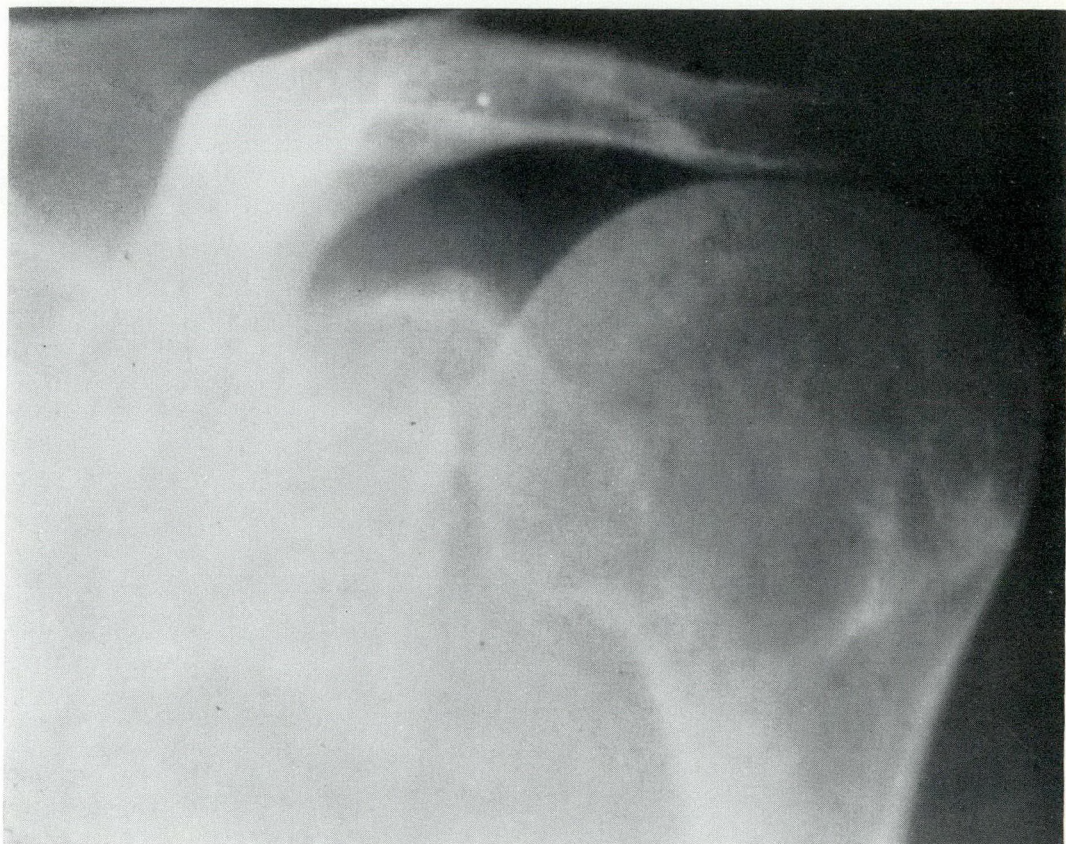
Radiograph showing upward migration of the head of the humerus in relation to the glenoid.
